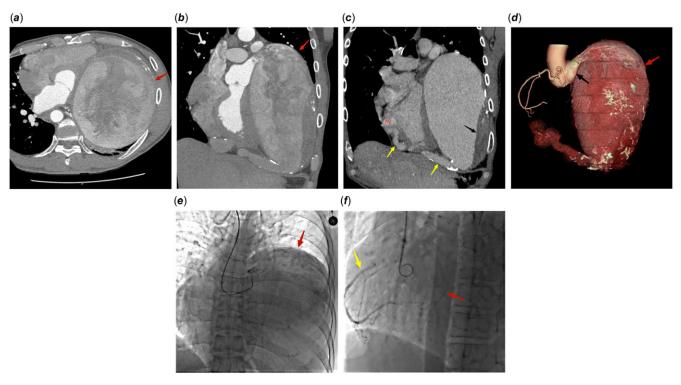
a,b* Coronary CTA showed a giant coronary aneurysm (GCAA) (red arrows). *c* Venous phase chest CT identified mural thrombosis (black arrows) in the aneurysm and a dilated and tortuous fistula (yellow arrows). *d* The 3D volume-rendering reconstruction highlighted the dilated left coronary sinus (black arrows) and dilated left coronary artery with a GCAA (red arrows). *e* Left coronary angiography in the anterior posterior projection revealed limited development of the aneurysm (red arrows) and the distal portion of the left coronary artery, attributed to the aneurysm's immense size. *f* Right coronary angiography in the left anterior oblique projection demonstrated that the left anterior descending coronary artery (red arrows) received retrograde supply from the right coronary artery (yellow arrows).
